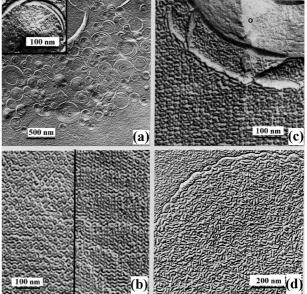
FFEM of glycolipid possessing a cyclopentane unit located at three methylene groups from the glyceryl unit, after hydration by intensive stirring in excess water (a, d) and gentle hydration at 95 wt.-% water content (b-c). a) Multilamellar onion-like vesicles are predominant. At larger magnification (inset), the multilamellar arrangement with a repeat distance of about 5 nm is visible. b) Two projections of a cubic 3D-structure with a repeat distance of the hexagonally arranged elements (tunnels, left part) of about 23 nm. c) Coexistence of a cubic phase structure and a multilamellar vesicle; sponge-like structured particles have not been found. d) Rarely detectable sponge-like structure after ultrasonication in excess water.
